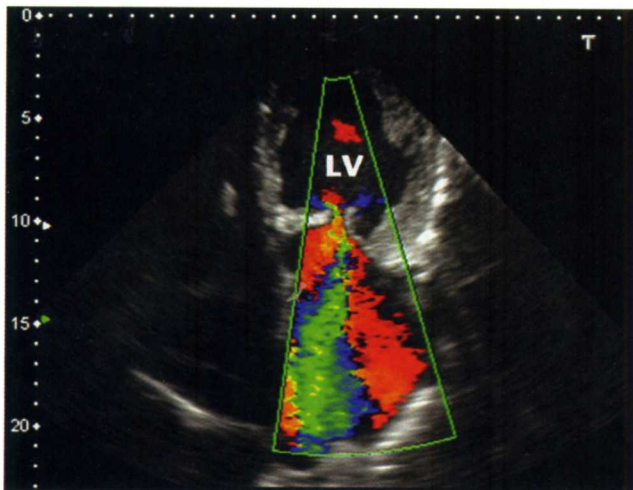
Mitral insufficiency. A shortened apical view with color Doppler demonstrates severe mitral regurgitation with turbulent flow. LV = left ventricle. (Courtesy of Hennepin County Medical Center)
